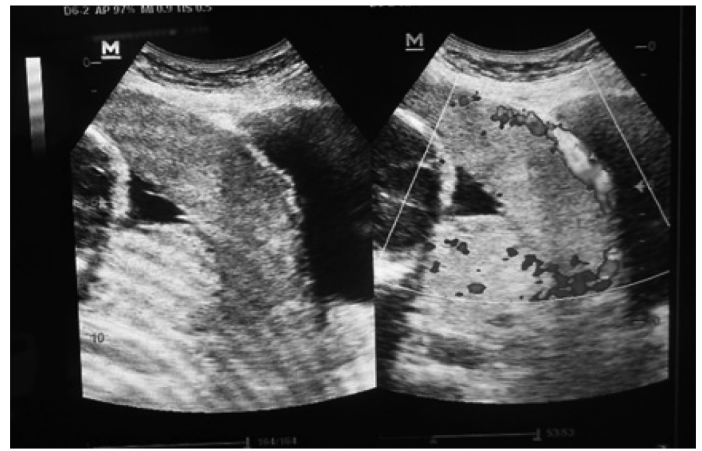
Transabdominal scan at 26 weeks showing a placenta totally covering the os and with sonographic findings suggestive of placenta accreta, possible percreta.
